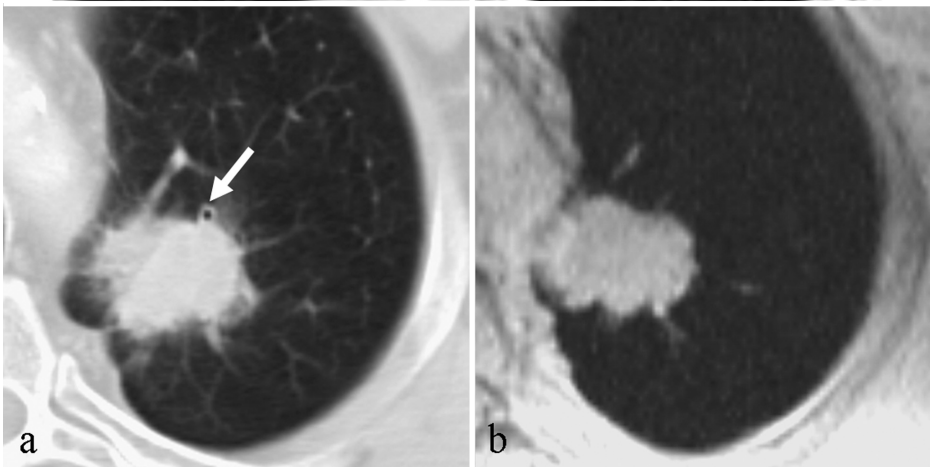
Images of a 47 year old man revealing a similarity of appearance in both methods showing spicules with extension to the pleura and pleura thickening. Note the adjacent bronchus (arrow) is not seen in MRI. The 35 mm mass was a squamous cell carcinoma. (a) CT, (b) MRI.
